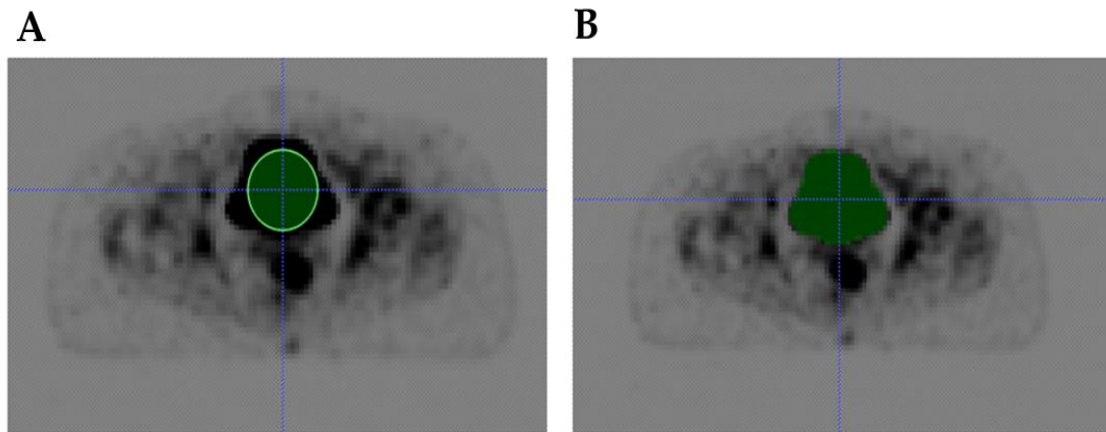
Extraction of the inner wall of the bladder from ^{18}F -FDG PET image using deformable models. Example created using ITK-SNAP software.
